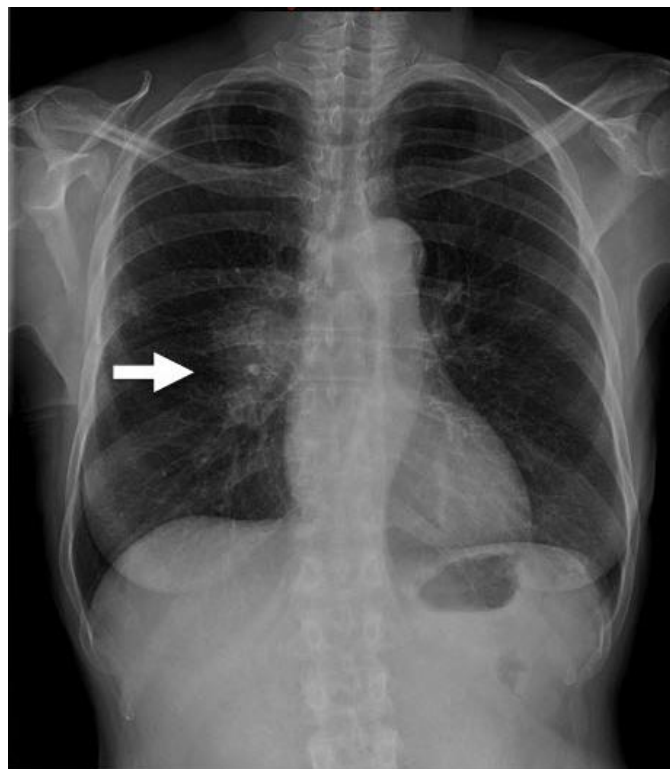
58 year old woman with Bazex syndrome presented with 2 year history of a hyperpigmented rash and a chest radiograph was obtained. Posteroanterior chest radiograph demonstrates enlarged right hilum due to adenopathy (arrow).
